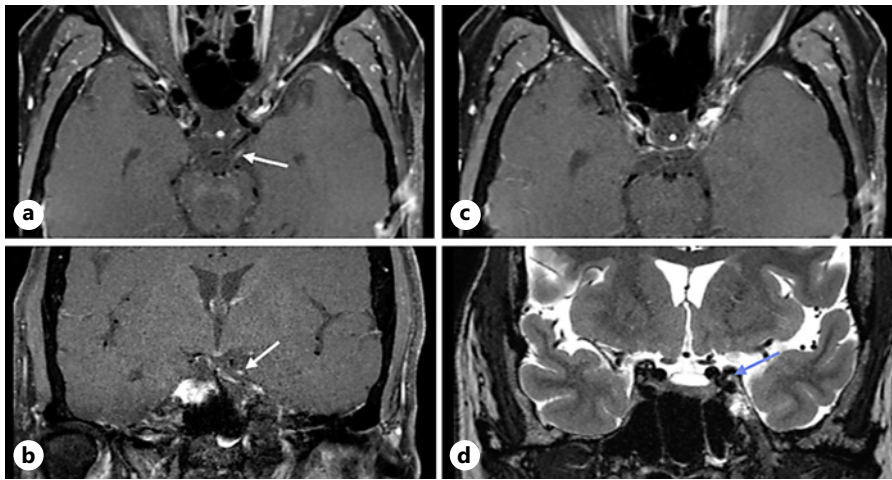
Axial (top) and coronal (bottom) magnetic resonance imaging with contrast of the third cranial nerve at presentation. This shows enhancement (white arrows) in the T1 postcontrast images and increased T2 signal (blue arrow) in the third cranial nerve.
